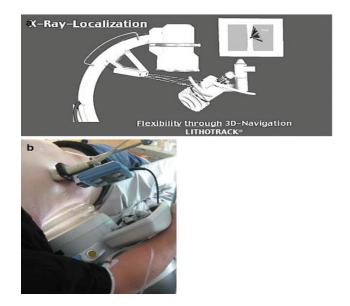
a) localization of renal stones by fluoroscopy b) localization of renal stones by fluoroscopy by ultrasound (24)
